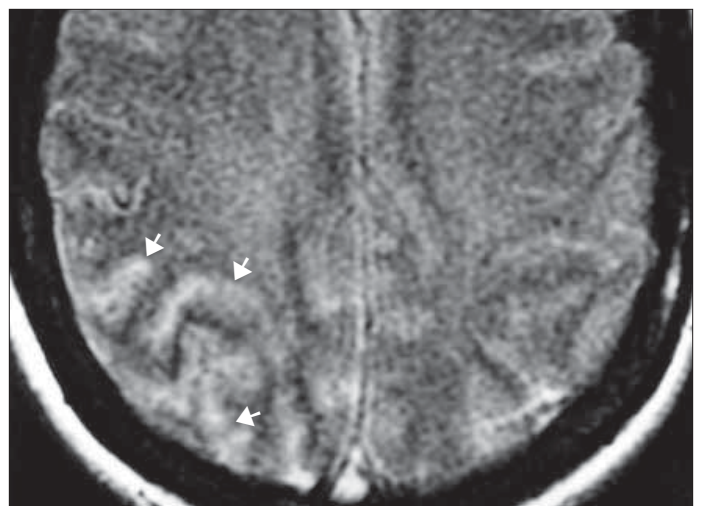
Axial fluid-attenuated inversion recovery (FLAIR) MR image demonstrates edema (arrows) in the right occipital lobe.
